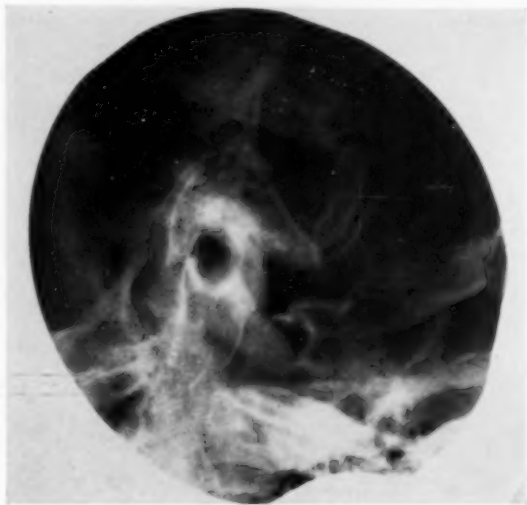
X-ray of a chronic mastoiditis showing extensive destruction and confluence of cells in the entire posterior aspects of the mastoid.
